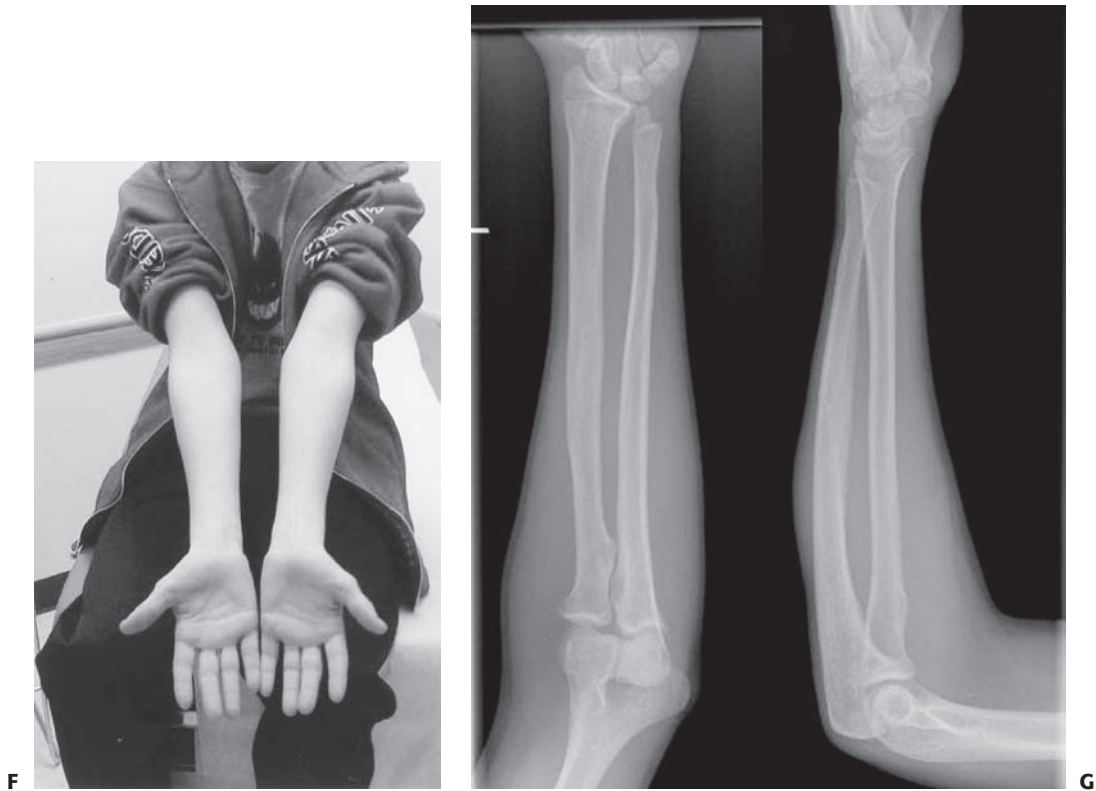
(continued) F: Axial alignment. G: Six-year follow-up radiographs with substantial remodeling of radius and ulna fractures.
